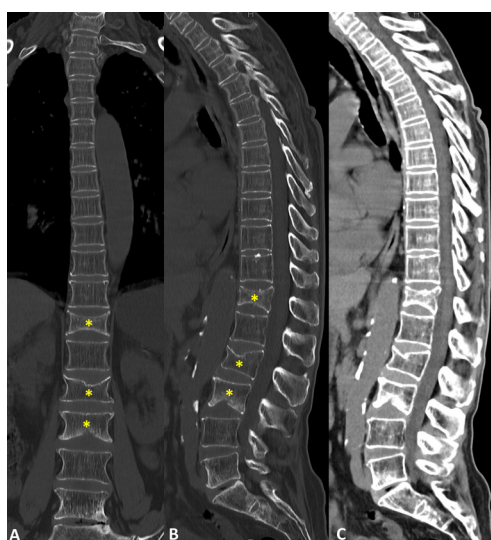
Coronal (A) and sagittal (B) non-enhanced CT reconstructions in bone window, acquired four days after symptom onset, demonstrate endplate compression fractures (yellow asterisks) involving T12, L2, and L3, which are symmetrical on the coronal plane. Sagittal non-enhanced CT reconstruction in soft-tissue window (C) shows no associated soft-tissue mass.
